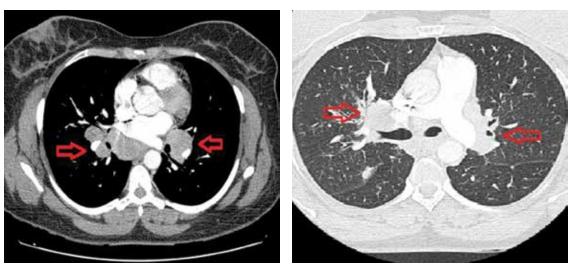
Computed tomography without contrast (left) shows multiple areas of lymphadenopathy in the mediastinum and lung hila (red arrows). The "lung window" view (right) shows a perilymphatic micronodular interstitial pattern, with thickened and nodular bronchial walls; the red arrows indicate areas of hilar lymphadenopathy.
